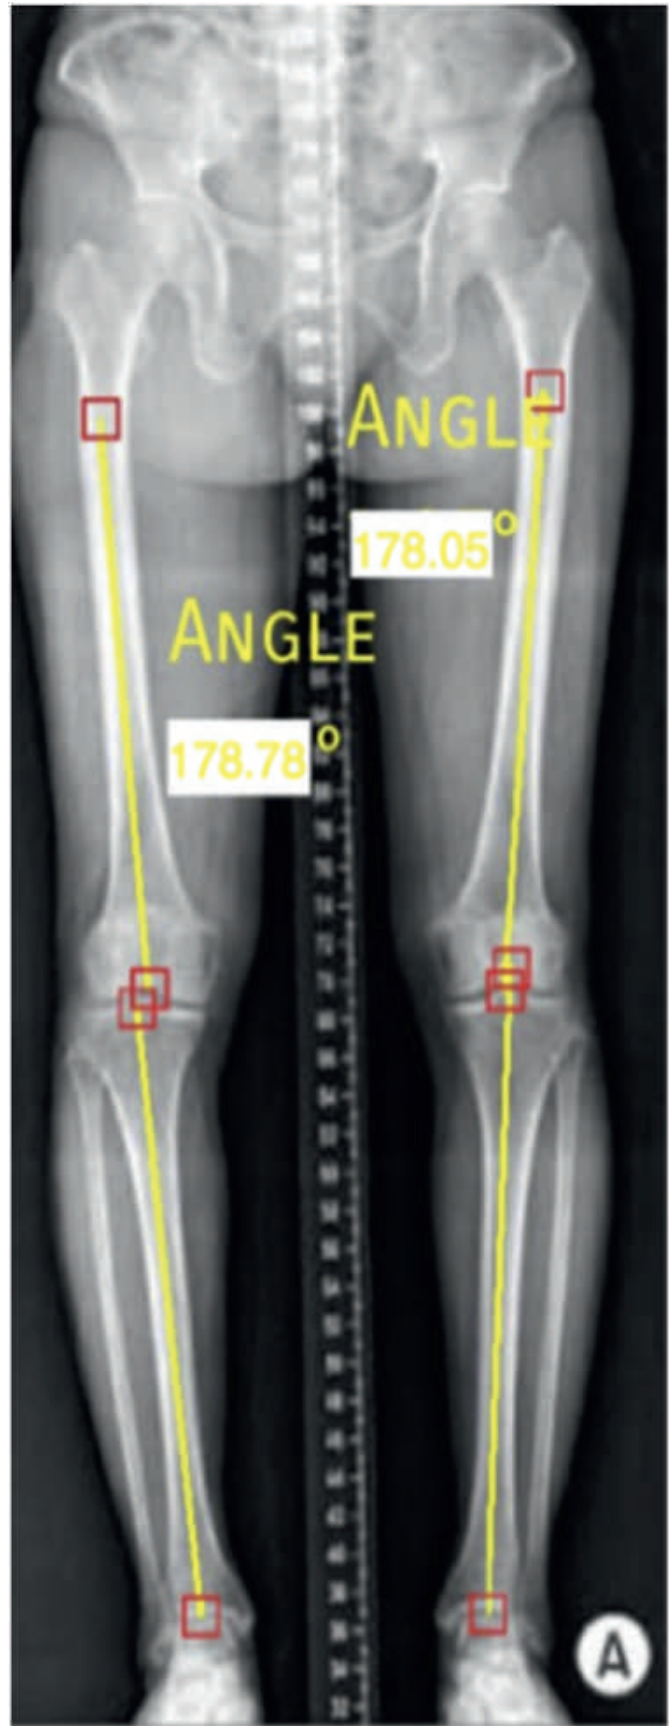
Pre Op Hip Knee Ankle Xray of a representative patient.
